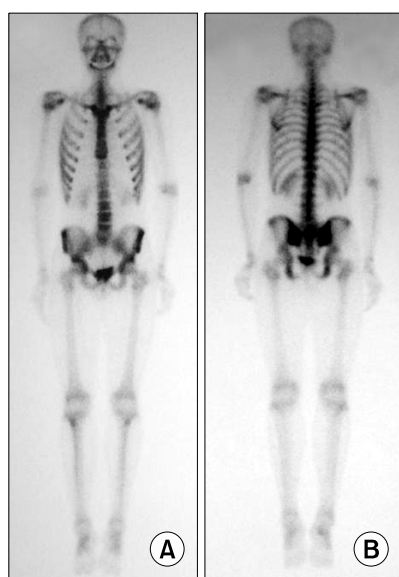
The bone scintigraphy taken 3 days after excision of the lesion. The absence of a hot spot on the anterior (A) and posterior (B) view implies that there is no acute fracture.
